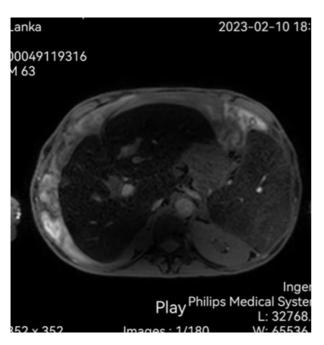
T2* gradient axial echo slice of liver MRI - This demonstrates an abnormal low signal intensity of the liver compared to erector spinae muscle (L/M ratio <0.9).
